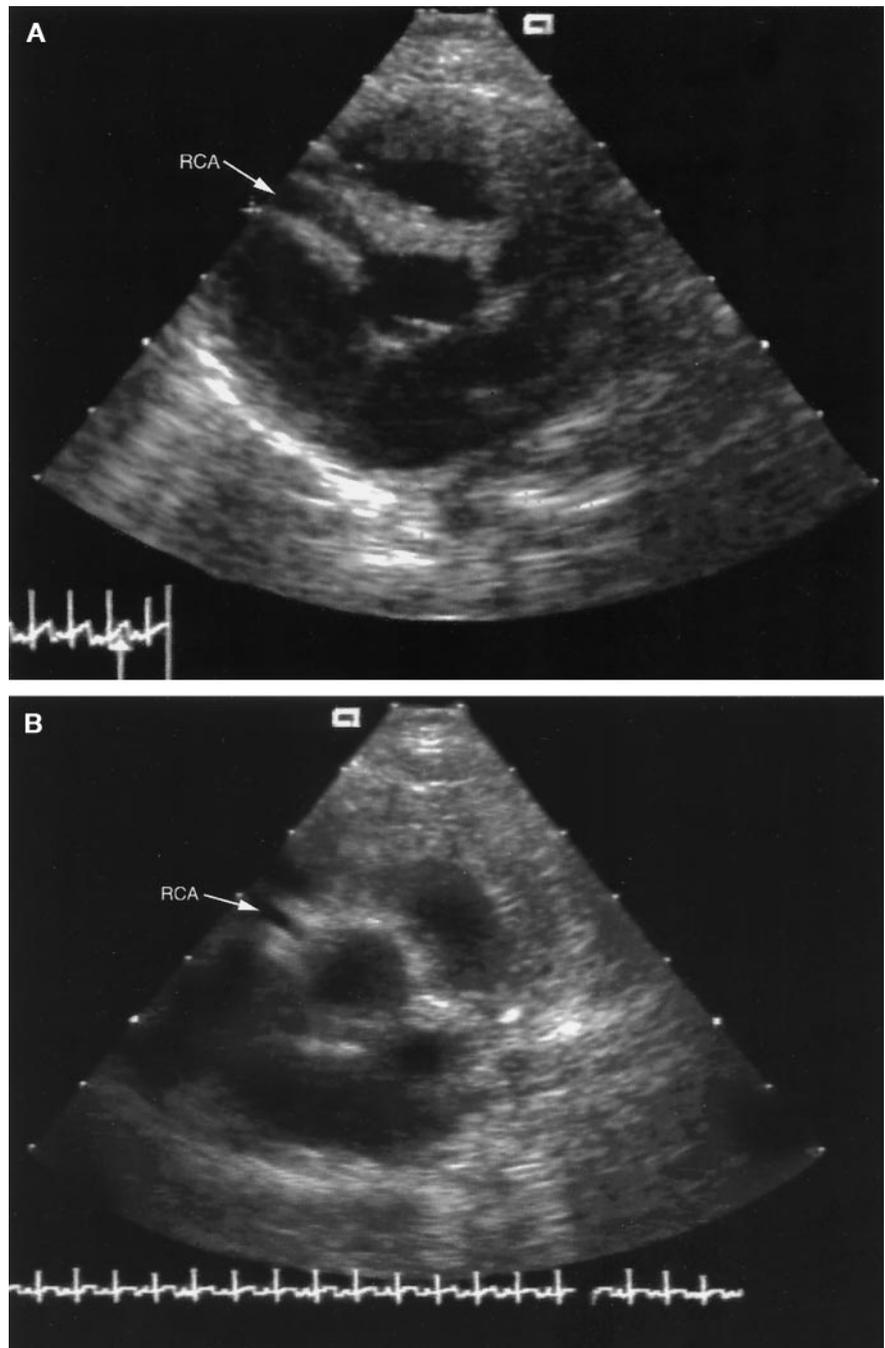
Echocardiographic images of an aneurysm of the right coronary artery from a patient who was treated with abciximab in the acute phase of the illness (A) and at early follow-up (B). Images were obtained from the parasternal short axis imaging plane, and the scale is the same in each image (scale markers are 10 mm). When acute and early follow-up images are compared, there has been a significant decrease in the lumen diameter of the fusiform aneurysm of the proximal right coronary artery. RCA, right coronary artery.
